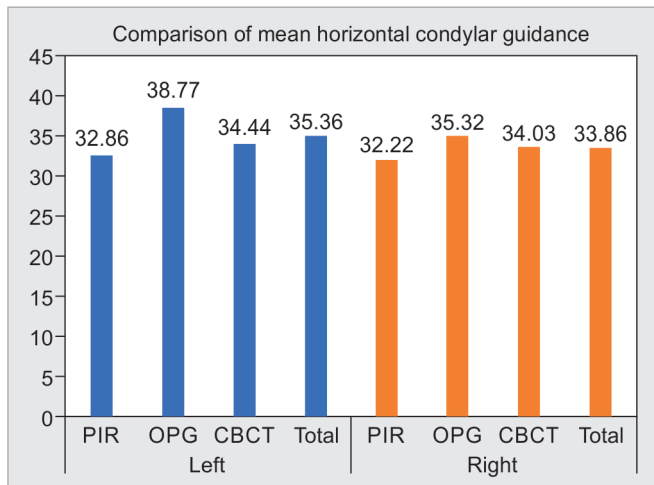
Comparisons of right and left HCGA of PIR, OPG, and CBCT
